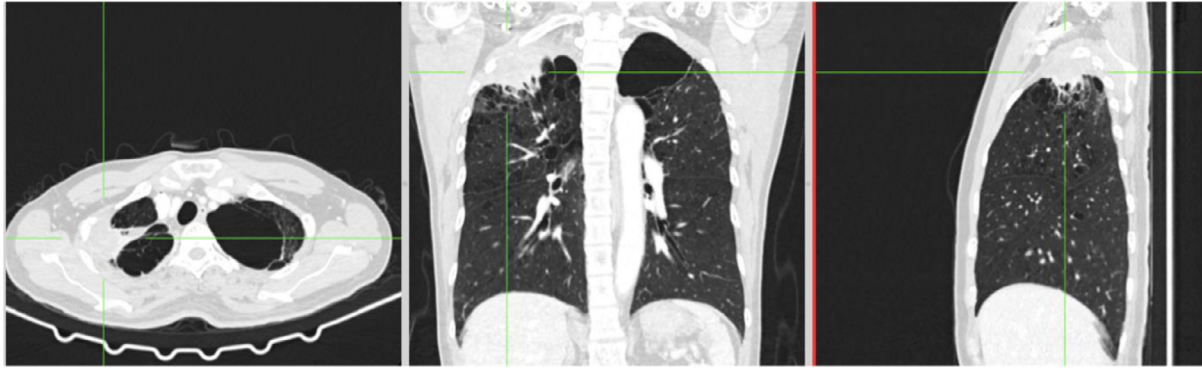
Contrast-enhanced CT-scan images of the chest region prior to tuberculosis medication depict a mass with heterogeneous contrast enhancement and fibro consolidation and cylindrical branch dilatation of the bronchial in the apical segment of the superior lobe of the right lung. Paraseptal and centrilobular emphysema in the superior lobe of the right and left lung are also noted.
